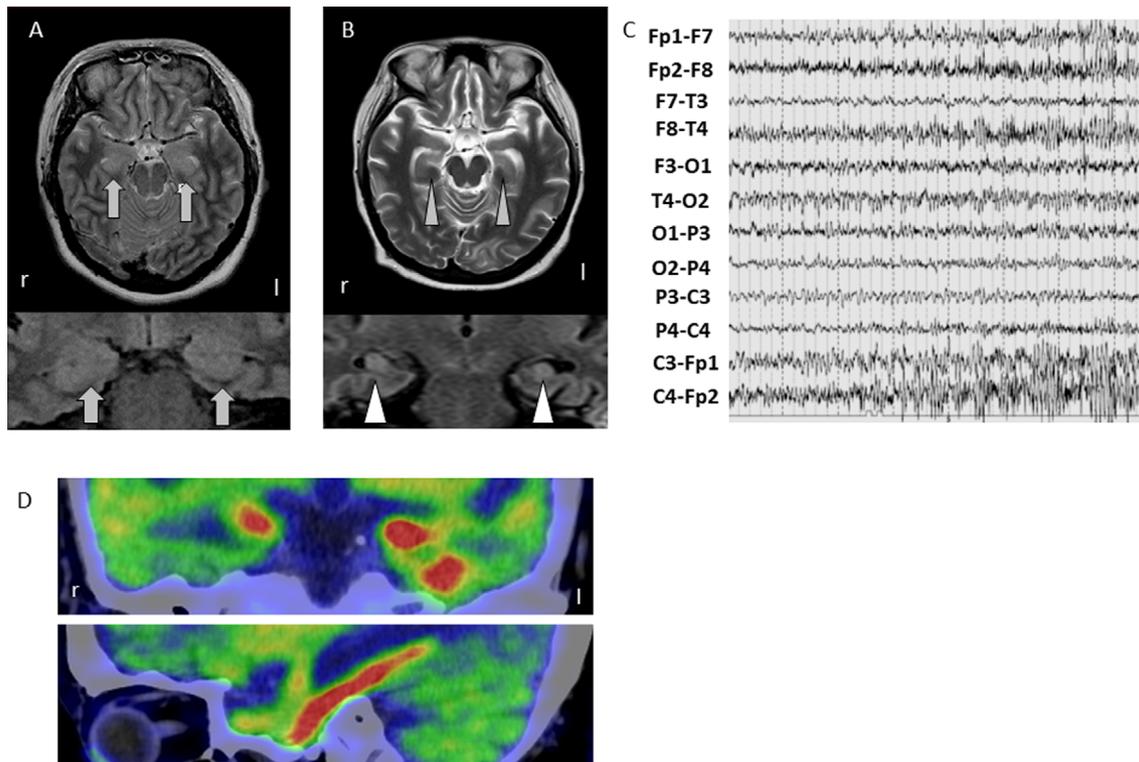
Findings of brain MRI, electroencephalogram and positron emission tomography. Axial T2-weighted brain MRI (A and B). (A) Brain MRI on admission revealed hyperintensities and swelling bilaterally in the hippocampi (white arrows) and cortices. (B) Brain MRI three months after admission showed bilateral progressive severe atrophic changes in the hippocampi (white triangles) and cortices, especially in the temporal lobes. (C) An electroencephalogram indicated diffuse high sharp waves and poly-spikes under thiopental sedation five months after admission. (D) Brain positron emission tomography with [^{18}F] fluorodeoxyglucose depicted hyper-metabolism in the bilateral hippocampi (above) and a widespread lesion in the temporal lobe, predominantly on the left side (below).
